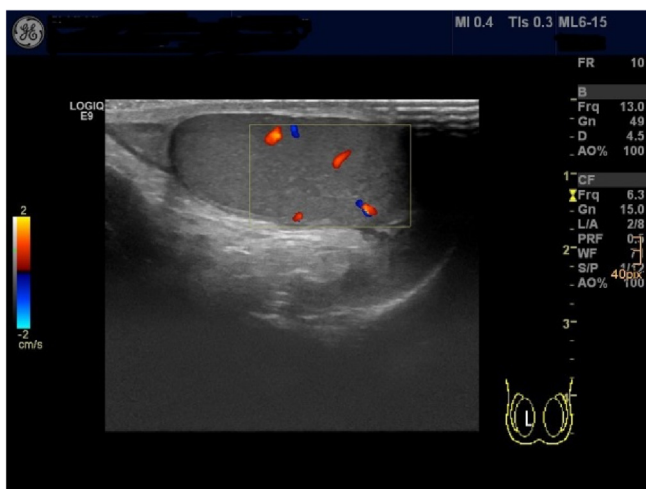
For comparison the sonographic aspect of the healthy right testicle with central perfusion and with a normal structure.
